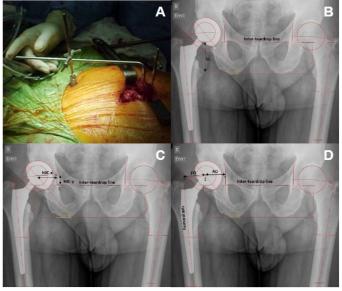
(A) Manual intraoperative LL confirmation; (B) trochanteric method of measurement of LL [3] on radiographs, as well as (C) hip joint centre (D) HO [4]. FO: femoral offset, AO: acetabular offset.
